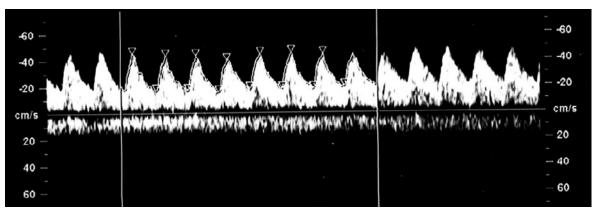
Normal umbilical artery Doppler velocimetry.
